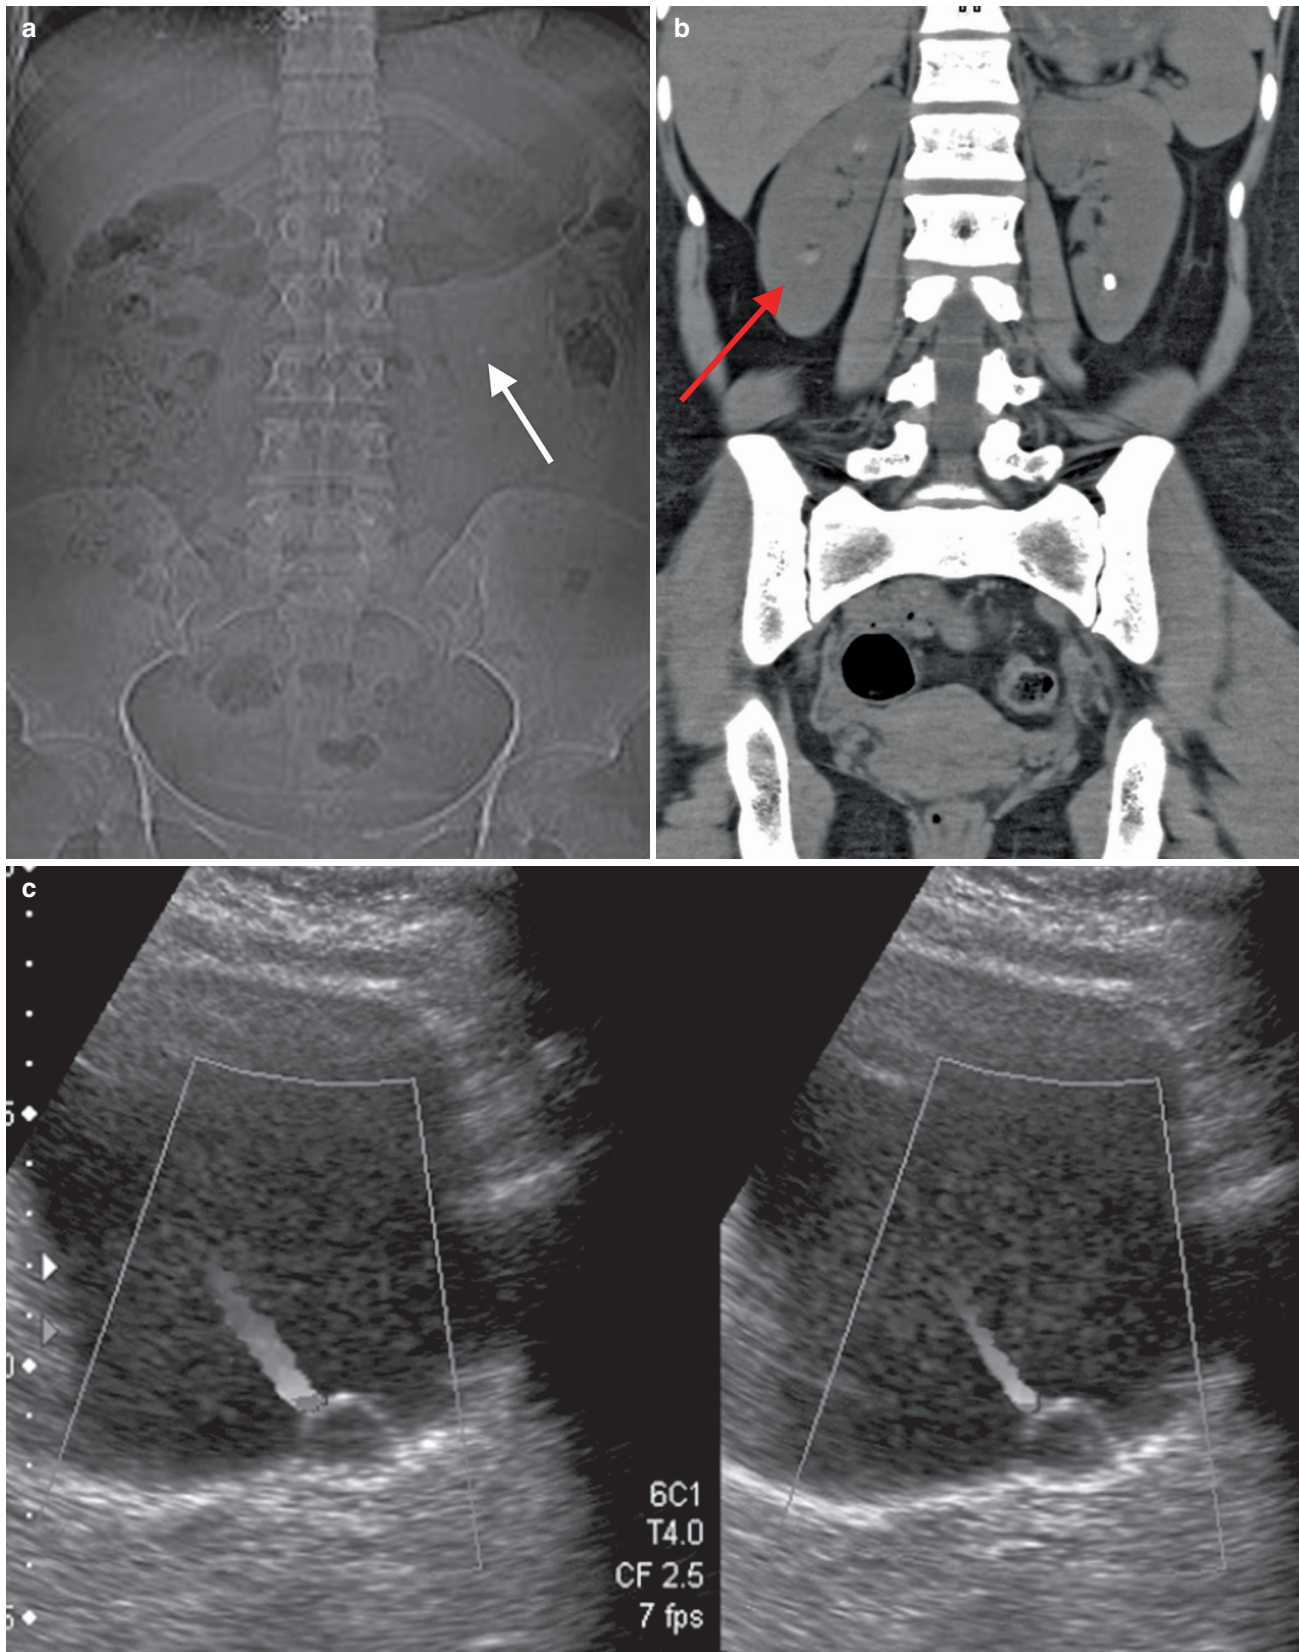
CT KUB. (a) The arrow points to nephrocalcinosis. (b) There is a faintly radio-opaque left renal stone (arrow). An interesting point is that the ureterocele was not detectable on this NCCT and would have been missed but for a previous ultrasound (c)
